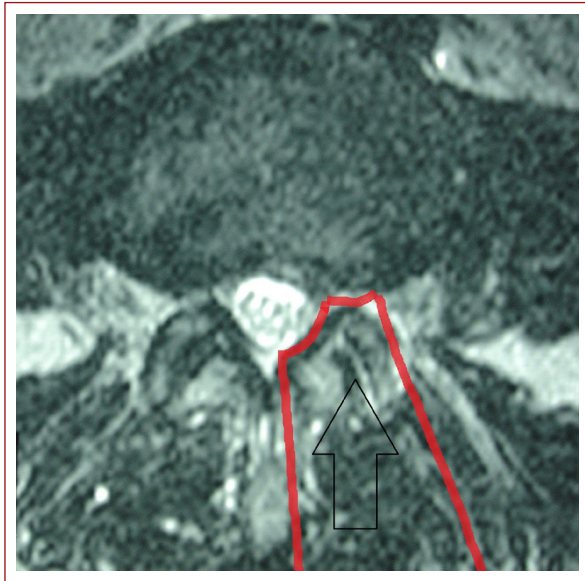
Axial MRI showing the access trajectory of a costotransversectomy toward the ventrolateral aspect of a vertebral body.
